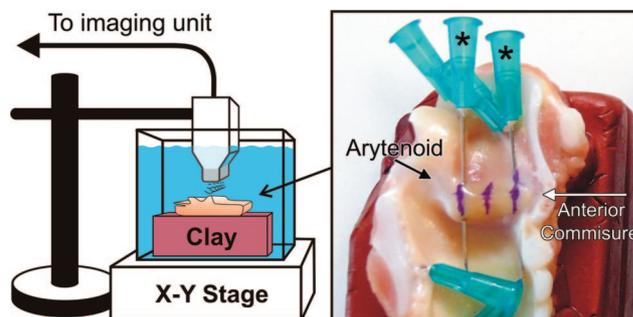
The experimental setup showing the hemi-larynx fixed to a clay block and immersed in physiological saline for imaging with the ultrasound probe. The left hemi-larynx with needles securing it to a clay block is also shown. Two needles (labeled with asterisks) are inserted from superior to inferior in the transverse plane through the anterior and posterior vocal fold, spaced approximately 10 mm apart.
